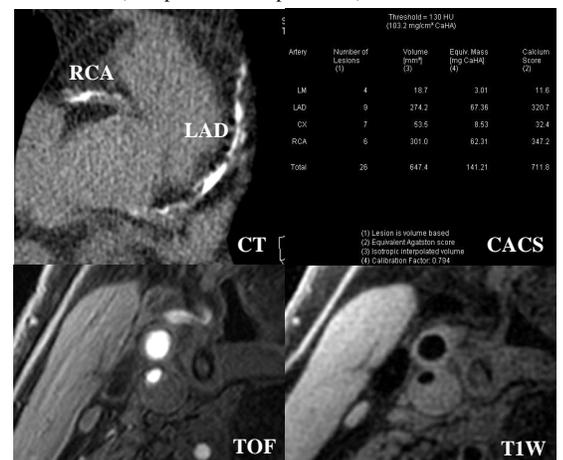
An example showed high CACS (CACS=711.8) on coronary artery CT images and larger WA and WT on the right internal carotid artery MR images in the same patient.
